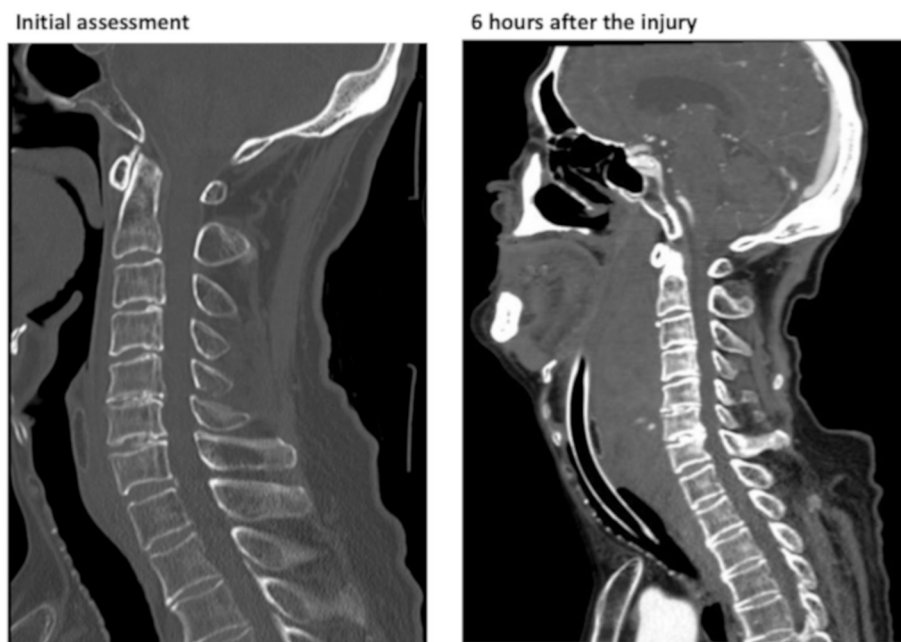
Cervical CT scan revealed no evidence of spinal fracture or abnormality of the retropharyngeal space at initial assessment. CT at 6 h after injury showed a retropharyngeal hematoma with extravasation in front of C6.
